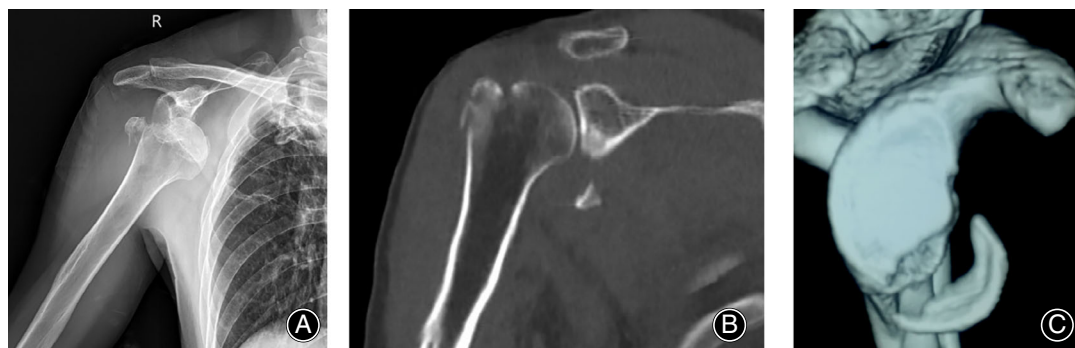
A 47-year-old female of this injury pattern. (A) Primary X-ray showing combination of glenoid and greater tuberosity fractures with traumatic shoulder dislocation. (B) Pre-operative coronal 2D CT image showing displacement of the glenoid and greater tuberosity fracture fragments. (C) Pre-operative 3D CT scan of the patient with marked displacement of the glenoid fracture fragment.
